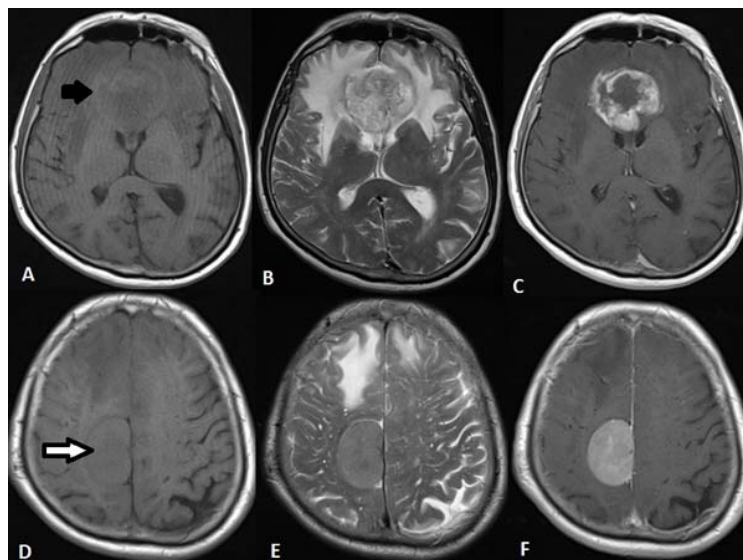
On axial plane T1- and T2-weighted brain MR, an isointense lesion is seen in both frontal lobes, infiltrating genu of corpus callosum (A-black arrow, B). Profound edema around it is seen (B). After IV contrast material, its rim enhances and a central necrotic area appears (C). Right parietal parasagittal dural based mass lesion is seen as isointense to cerebrum on T1- and T2-weighted scans (D-white arrow, E). It enhances homogeneously with IV contrast material (F).
